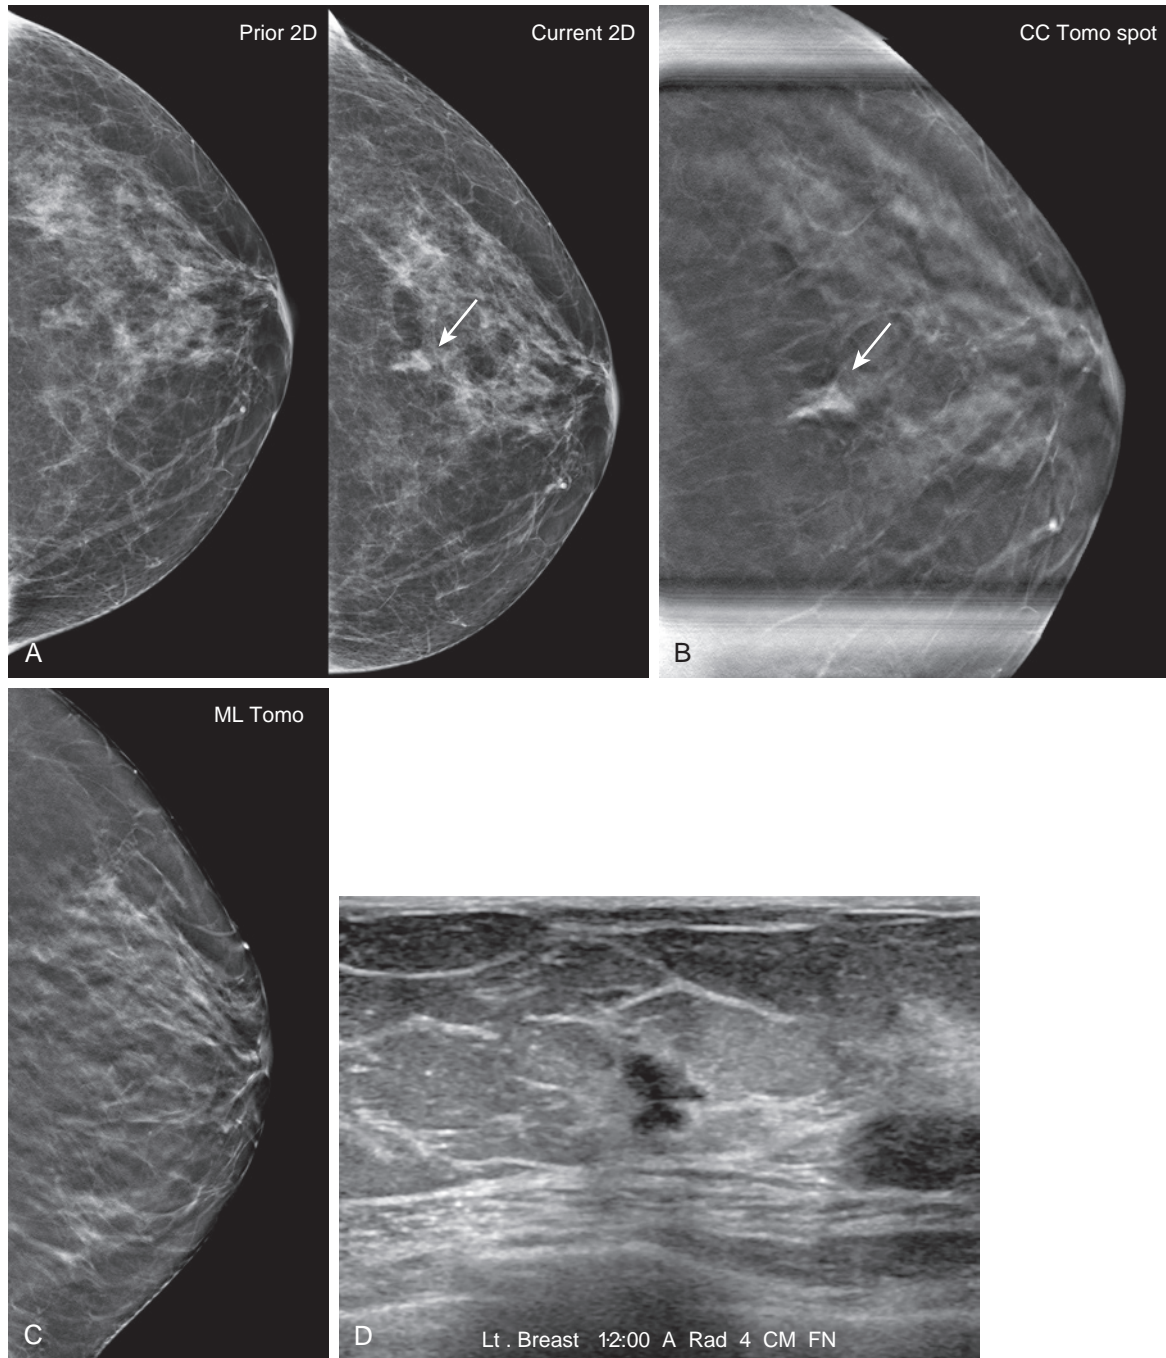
Carcinoma presenting as a developing asymmetry. A 61-year-old woman was recalled from a screening tomosynthesis mammogram. (A) A developing asymmetry (*arrow*) was noted centrally on the CC view in 2D images, more prominent than the previous mammogram. (B) The tomosynthesis spot slice image also showed a focal asymmetry but without spiculated margins (*arrow*), which located the lesion on the upper breast. (C) No definite mass could be seen on the ML (90-degree lateral) tomosynthesis views. (D) Ultrasound, however, showed a corresponding irregular taller-than-wide hypoechoic mass at the 12-o'clock region. Ultrasound-guided biopsy showed moderately differentiated invasive ductal carcinoma.
